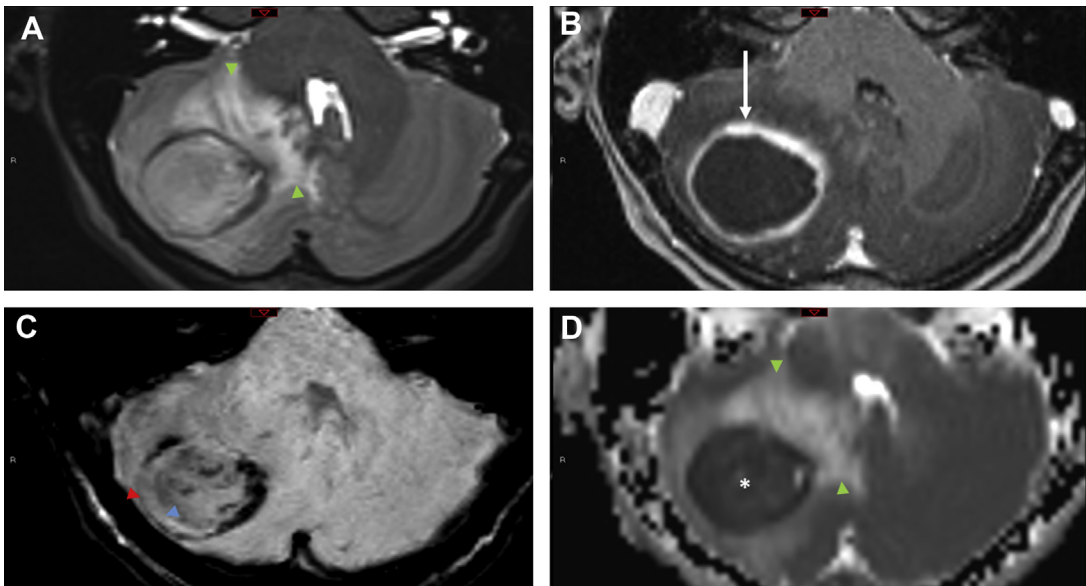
Pyogenic abscess. Axial T2-weighted (*A*), axial postcontrast T1-weighted (*B*), axial SWI (*C*), and axial ADC map (*D*) MR images in a 10 year old presenting with headache. Vasogenic edema (*green arrowheads* in *A* and *D*) surrounds the smoothly rim-enhancing right cerebellar mass (*white arrow* in *B*). A partial dual rim sign is displayed on SWI as an inner hyperintense rim and an outer hypointense rim (*blue* and *red arrowheads* in *C*, respectively). The central abscess cavity shows nearly homogeneous diffusion restriction as low signal intensity on ADC (*asterisk* in *D*).
